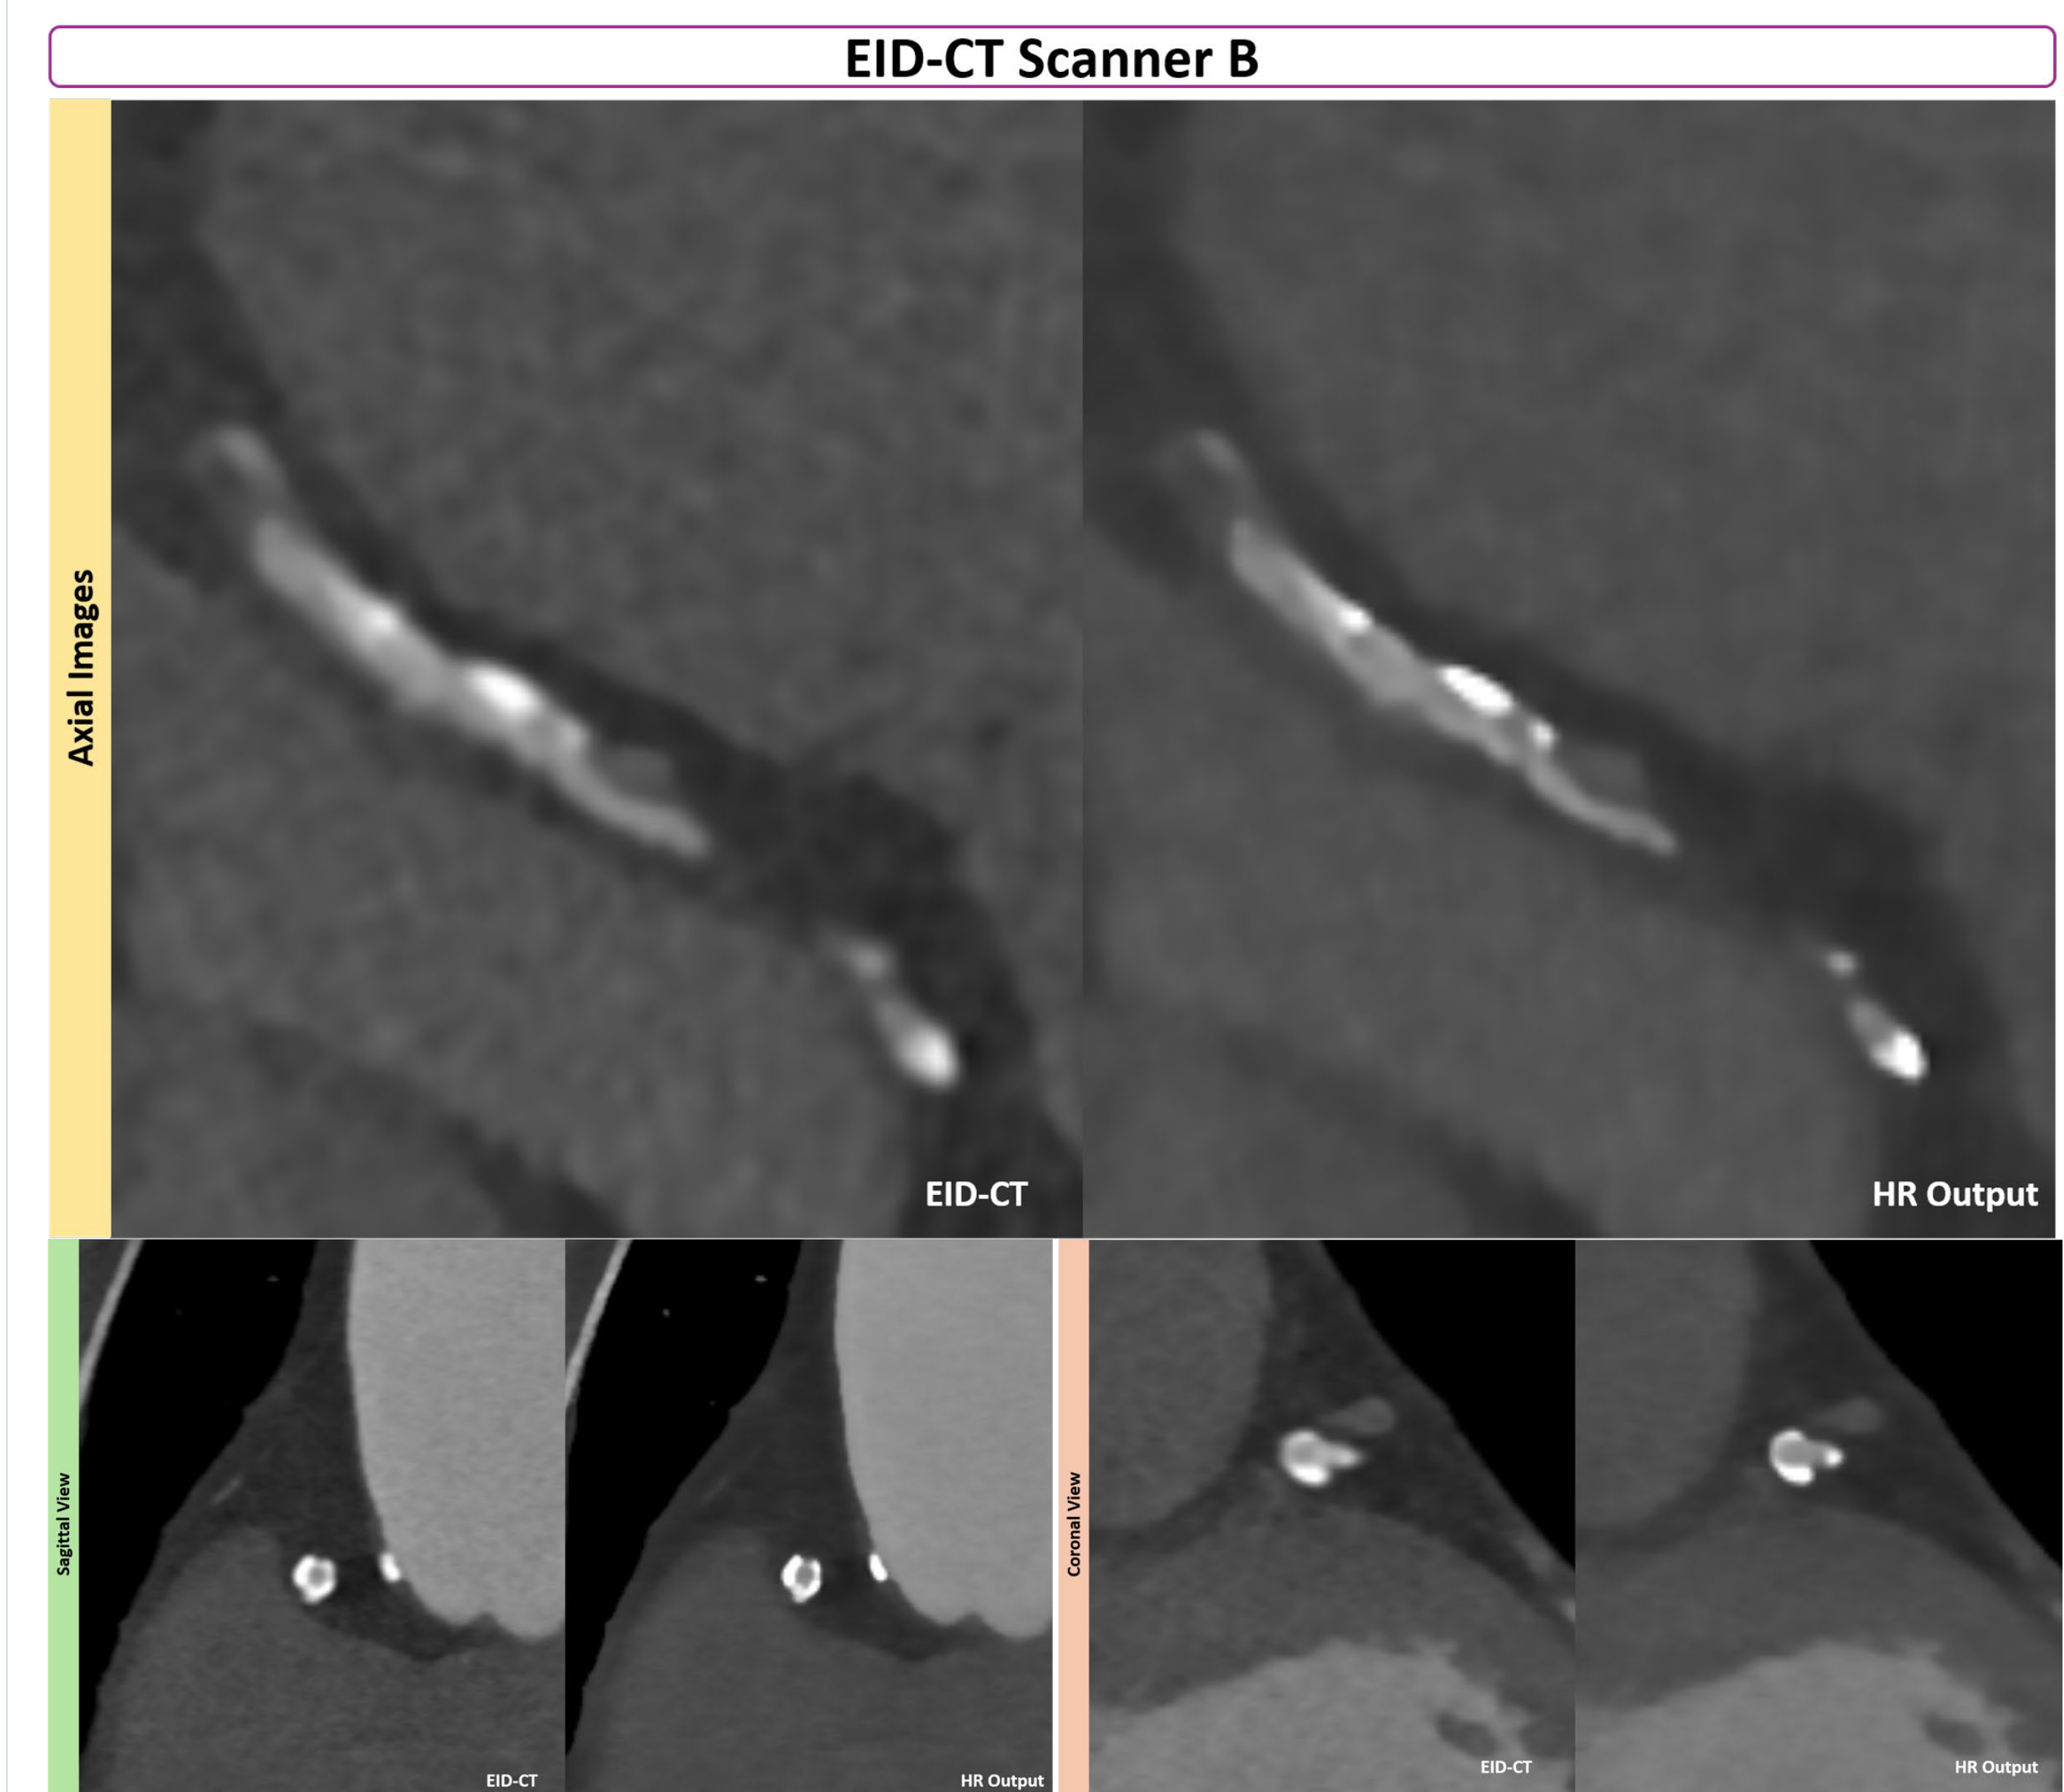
Representative cCTA case from a Flash Scanner. The HR output shows sharper calcified plaque margins, clearer coronary artery boundaries, and reduced blooming artifacts compared with input EID-CT. These results demonstrate the generalizability of the protocol-aware model across different EID-CT scanners.
